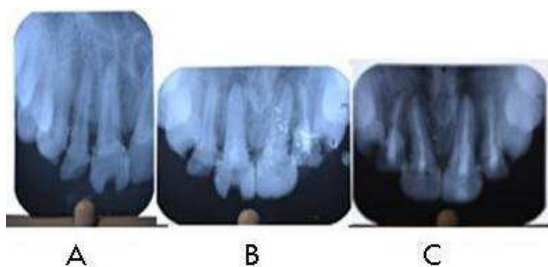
Pre, mid and post treatment radiograph
